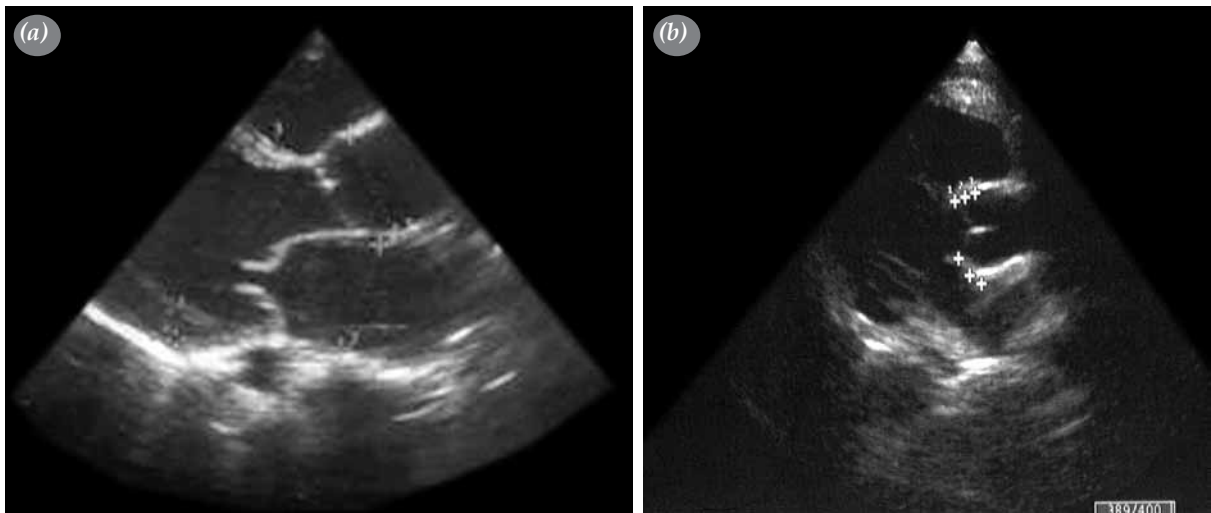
(a) Preoperative echocardiography shows severe heart failure. (b) Postoperative control echocardiography shows normal ventricular functions and normal donor's aortic root.
